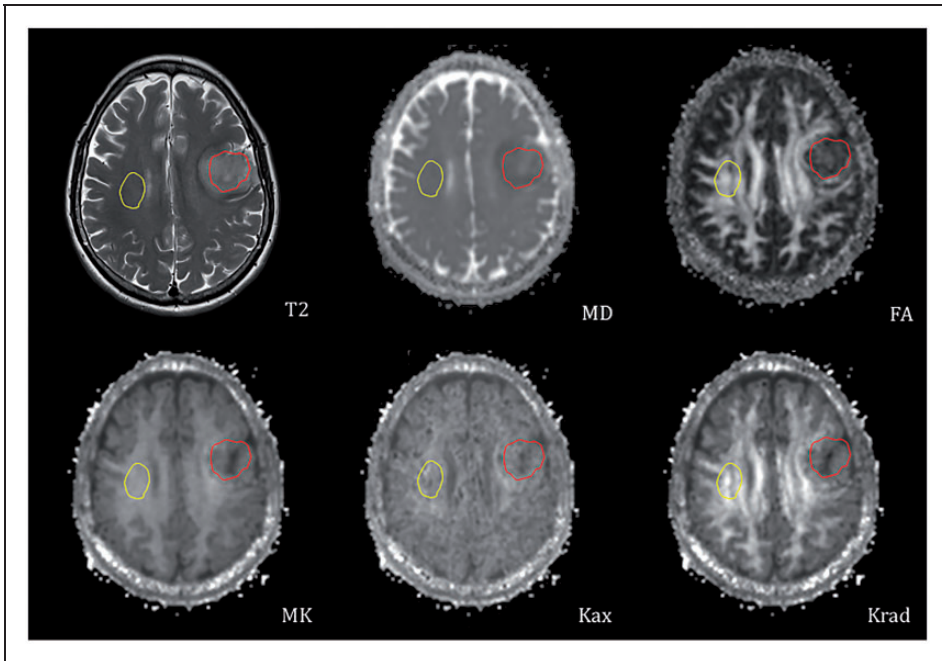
T2-weighted image and corresponding diffusion kurtosis parametric maps (MD, FA, MK, Kax and Krad) for a 60-year-old male with WHO-III glioma. Regions of interest (ROIs) were drawn in the solid part of the tumor (red) and contralateral normal appearing whiter matter (yellow), respectively.
